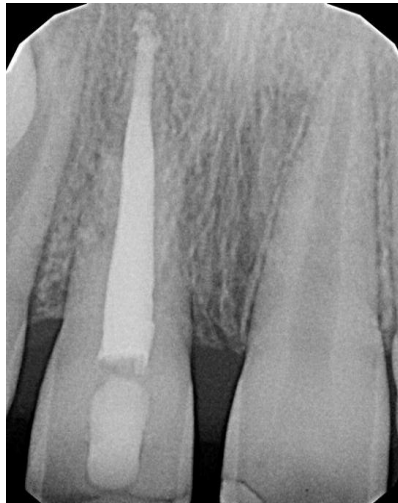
Post-operative intraoral periapical radiograph taken after 3 months, to ascertain alignment of tooth and apical positioning
